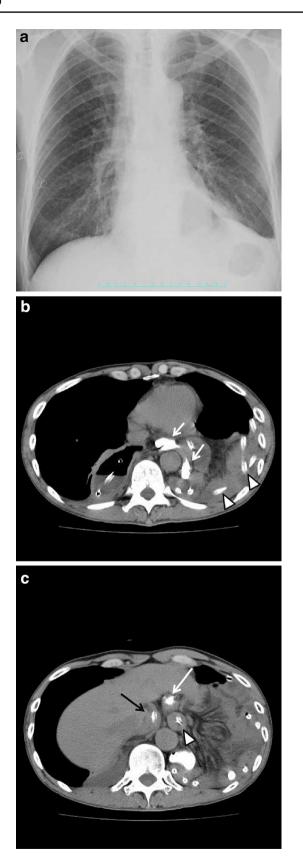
Chest roentgenogram of Patient #1 shows bowel gas overlapping with cardiac shadow (a). Computed tomography reveals diaphragmatic herniation to the left hemithorax containing transverse colon (*white arrow*) and jejunum containing ileus tube (*white arrow* head) (b). Transverse colon and jejunum herniating via the enlarged hiatus (*black arrow* gastric conduit) (c)
